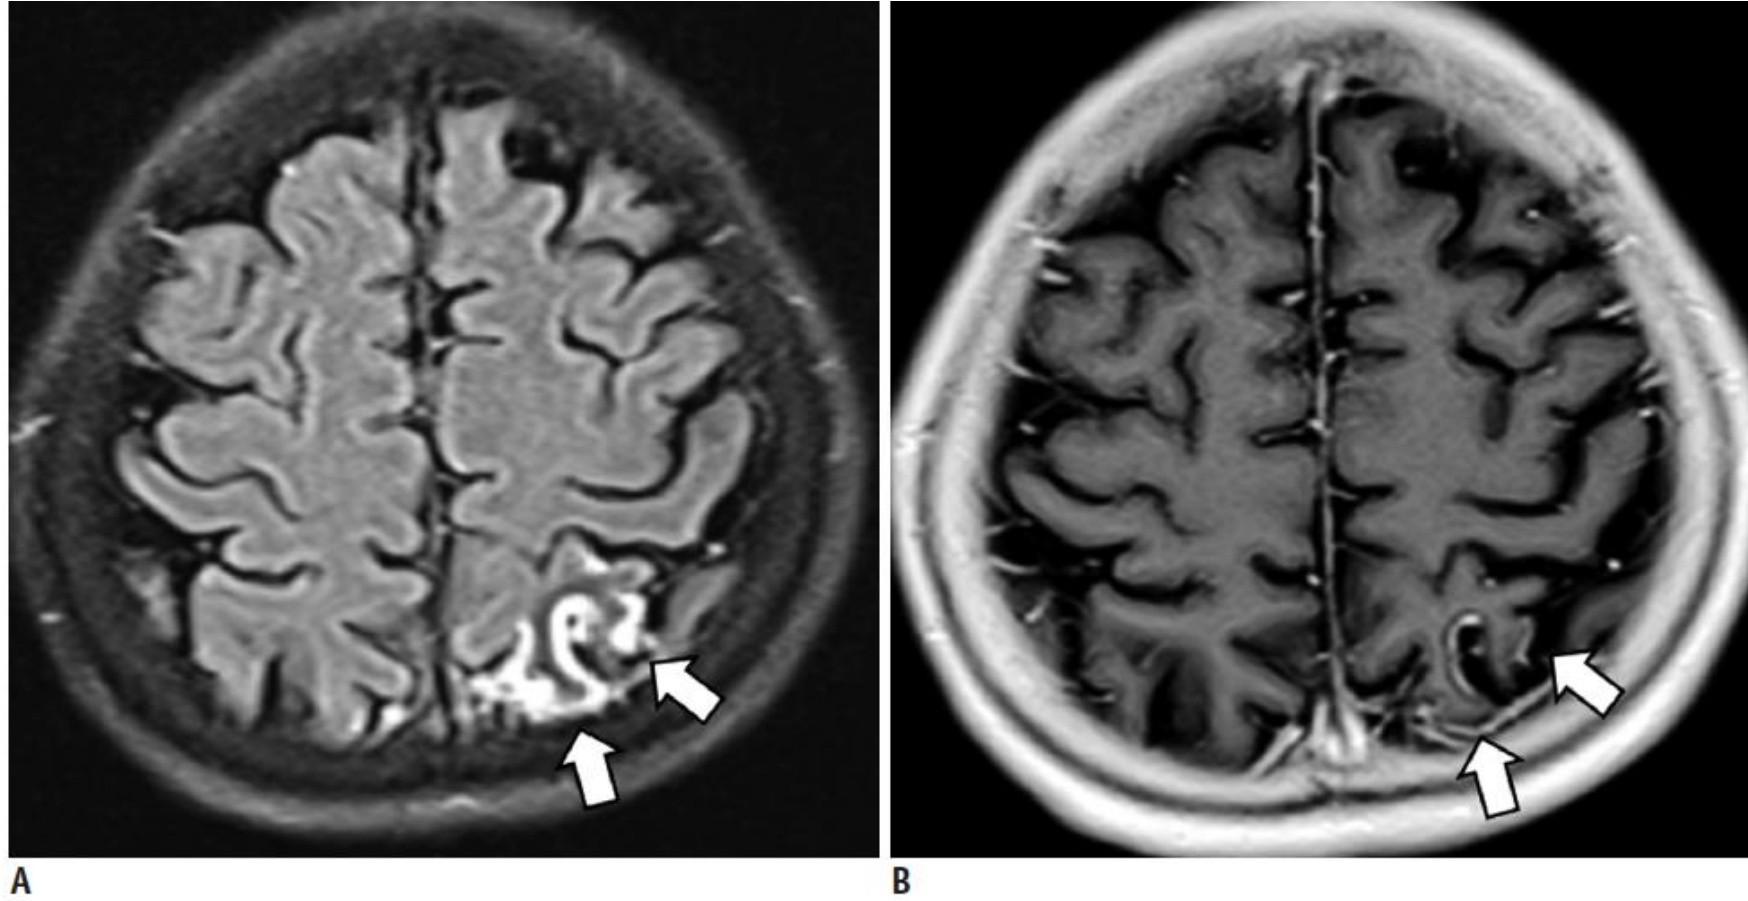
Seizures associated with nonketotic hyperglycemia. CE-FLAIR imaging (A) depicts focal subcortical hypointensity with overlying prominent cortical and leptomeningeal enhancement (arrows) in left parietal area. CE-T1WI (B) shows inferior enhancement (arrows) to CE-FLAIR imaging. Follow-up CE-FLAIR images 6 weeks later show remarkable resolution of subcortical hypointense lesion and abnormal enhancement (not shown). CE = contrast-enhanced, FLAIR = fluid-attenuated inversion recovery, T1WI = T1-weighted imaging
